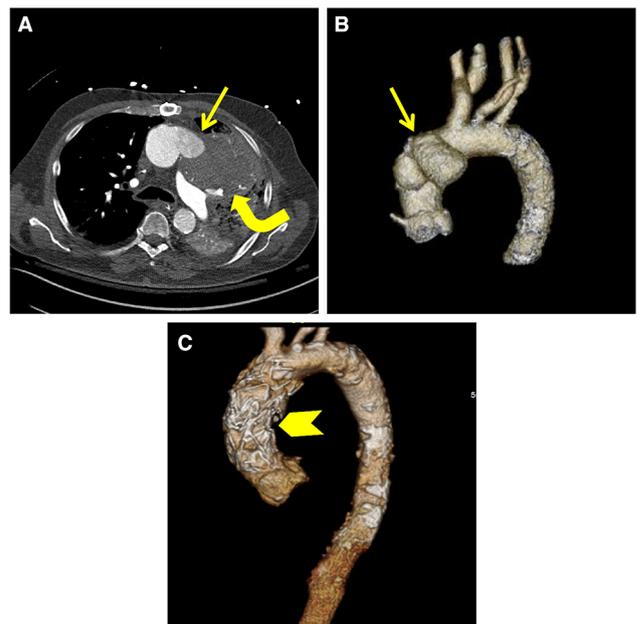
Post-operative pseudoaneurysm. a Axial CTA image of a patient following coronary artery bypass grafting. Images demonstrate a large pseudoaneurysm along the ascending aorta (arrow), with an associated large mediastinal hematoma (curved arrow). b 3D surface reformat shows the bi-lobed shape of this pseudoaneurysm, located along the ascending aorta (arrows). c Due to multiple comorbid conditions, this patient was not considered a candidate for re-do sternotomy and open repair. 3D surface reformat after Zone 0 TEVAR demonstrates a new stent graft along the ascending aorta, upstream of the arch vessels (arrowhead)
